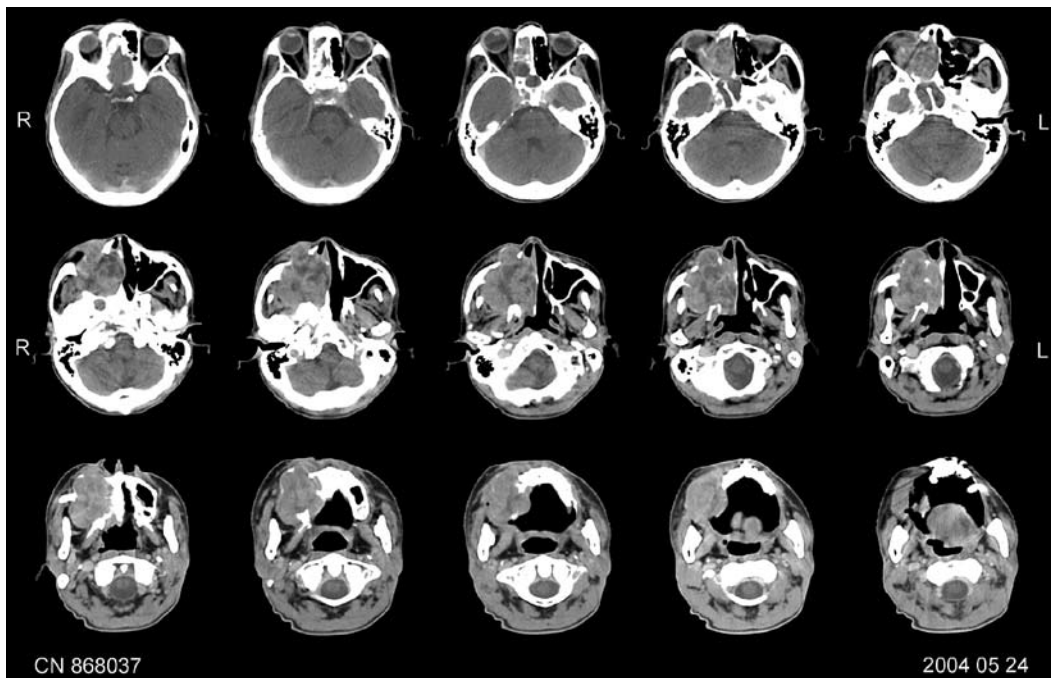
Axial CT scan of the patient before IMRT
